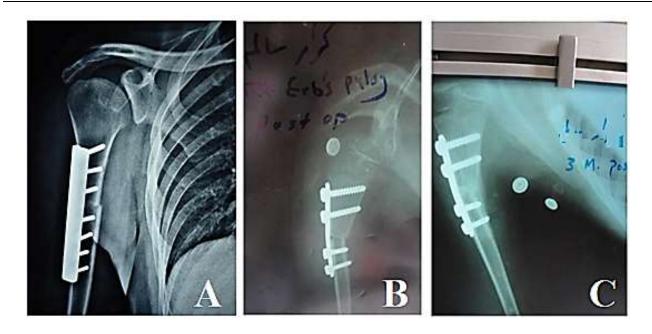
Post-op. X-rays for two patients in our study; A- Immediately post-op.; B and C - Immediately post-op. and 3 months post-op. respectively for other patient.
